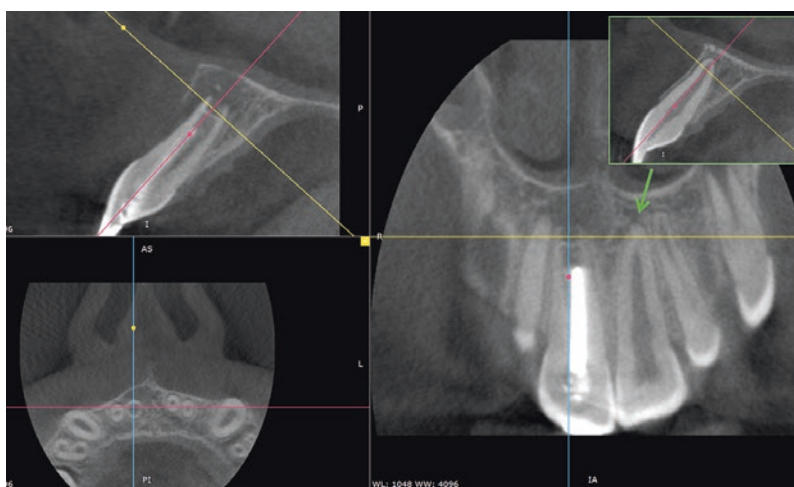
This is a case of trauma in the permanent dentition with open apices. The right-hand-side maxillary central incisor was not healing according to plan and a large inflammatory lesion developed at its apex, destroying almost the entire buccal cortical wall anterior to that tooth's root. A conventional two-dimensional radiograph would never be able to show the extent of the bone destruction. As such this CBCT is definitely beneficial as proper assessment of the situation can take place and an appropriate treatment can be executed. In the upper right corner of the image, the left-hand-side central incisor is shown and one can appreciate the nice image of the thin layer of buccal cortical bone over the root of that tooth (courtesy of Dr. Stephane Diaz, France)
